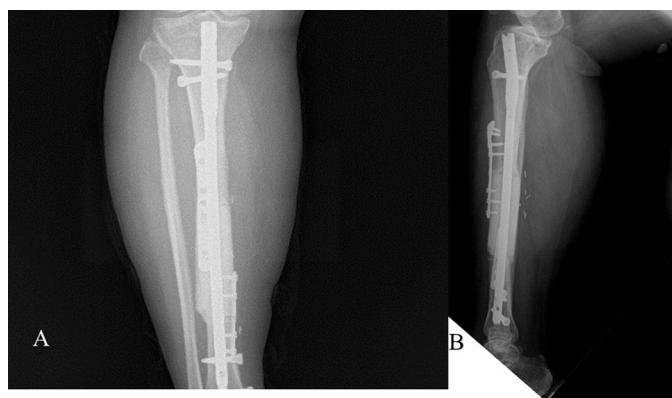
Anterior-posterior and lateral X-rays showing tibia healed at postoperative first year.
